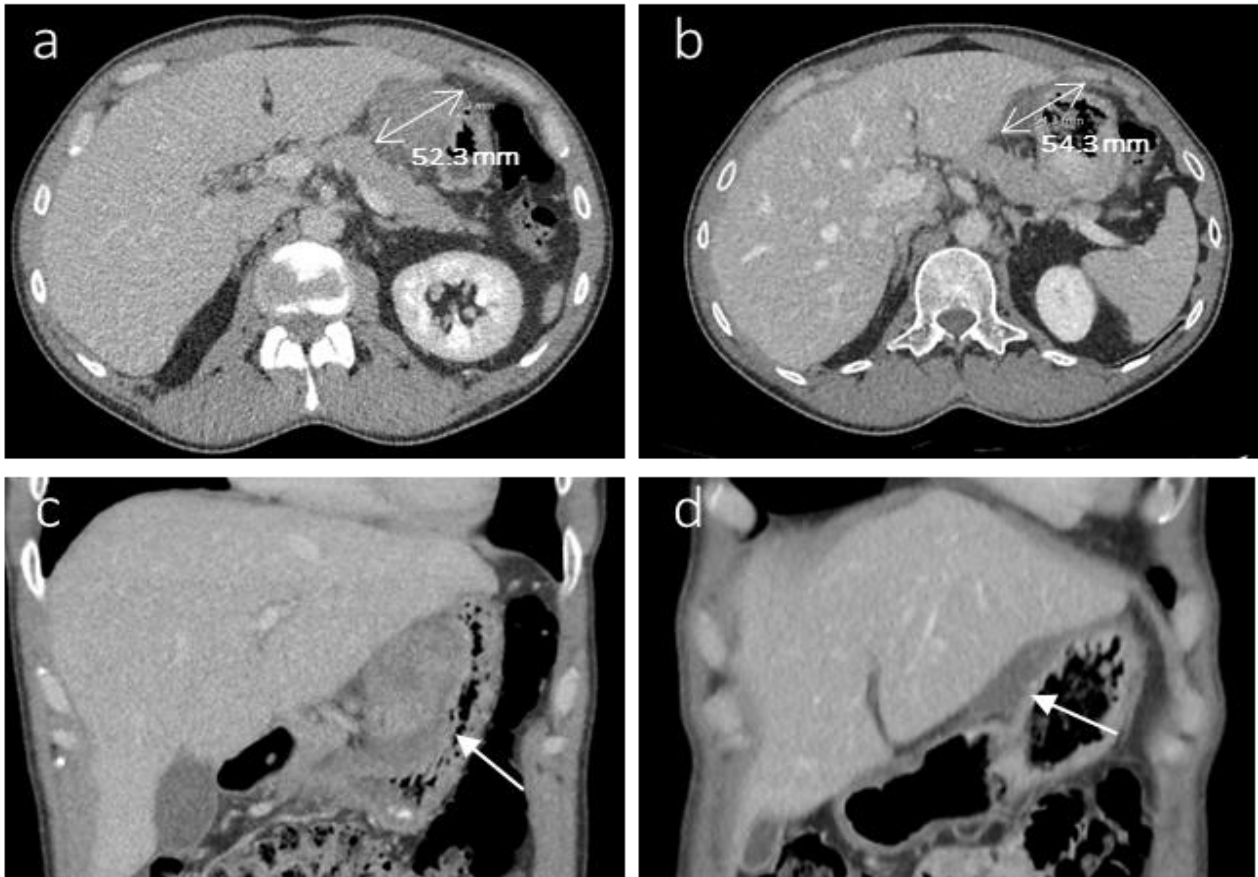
a) Axial portal venous phase CE-CT image of a 45-year-old male diagnosed with a gastric GIST. Before treatment induction, the transaxial tumour diameter measured 52.3 mm. b) After 6.8 months of TKI treatment, the transaxial RECIST tumour diameter equalled 54.3 mm, suggesting minimal to no response to systemic treatment. However, when looking at the coronal portal venous CT image, a significant decrease in tumour volume (arrows) can be observed between the c) pre-therapy and d) final preoperative response scan. The percentage change in tumour volume equalled 82.4%. RECIST measurements underestimated the therapeutic effect of TKI treatment in this patient.
